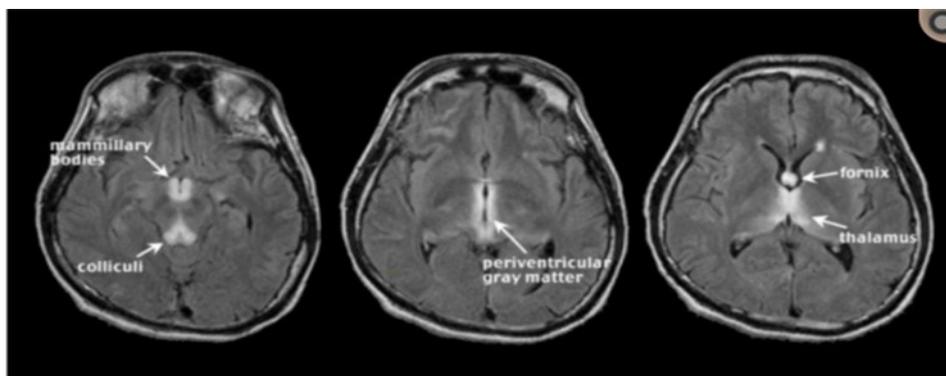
MRI of a patient diagnosed with Wernicke encephalopathy.
